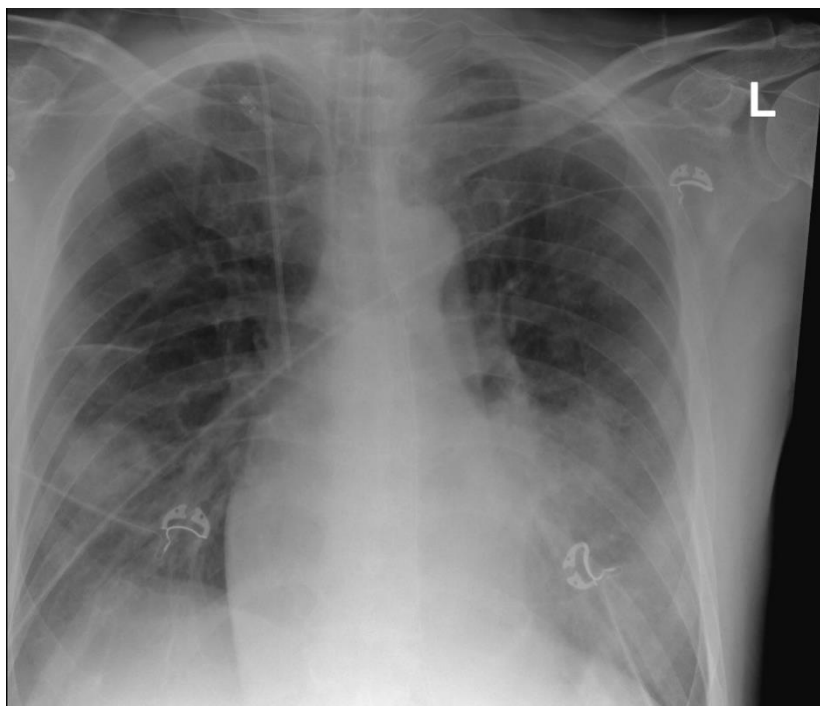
Chest X-ray showing bilateral pleural effusion and consolidation in the left lung.
